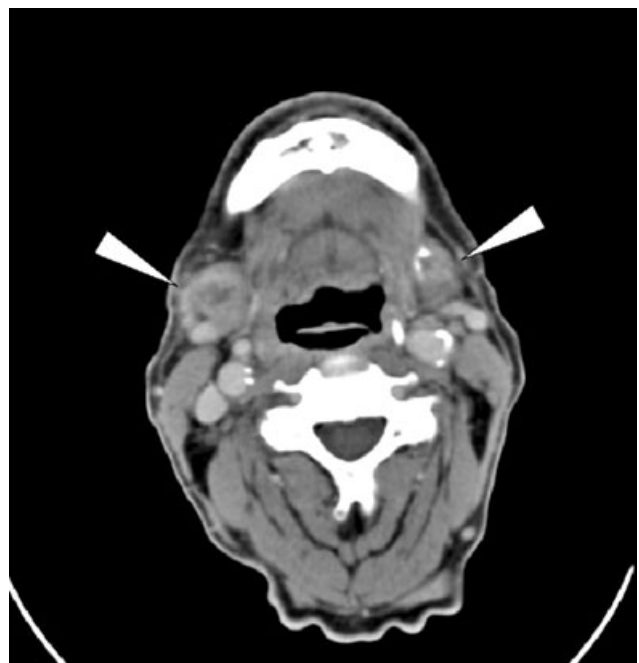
Computed tomography of the submandibular region with bilateral swollen submandibular glands (arrows). No typical signs for malignant growth were noted.
